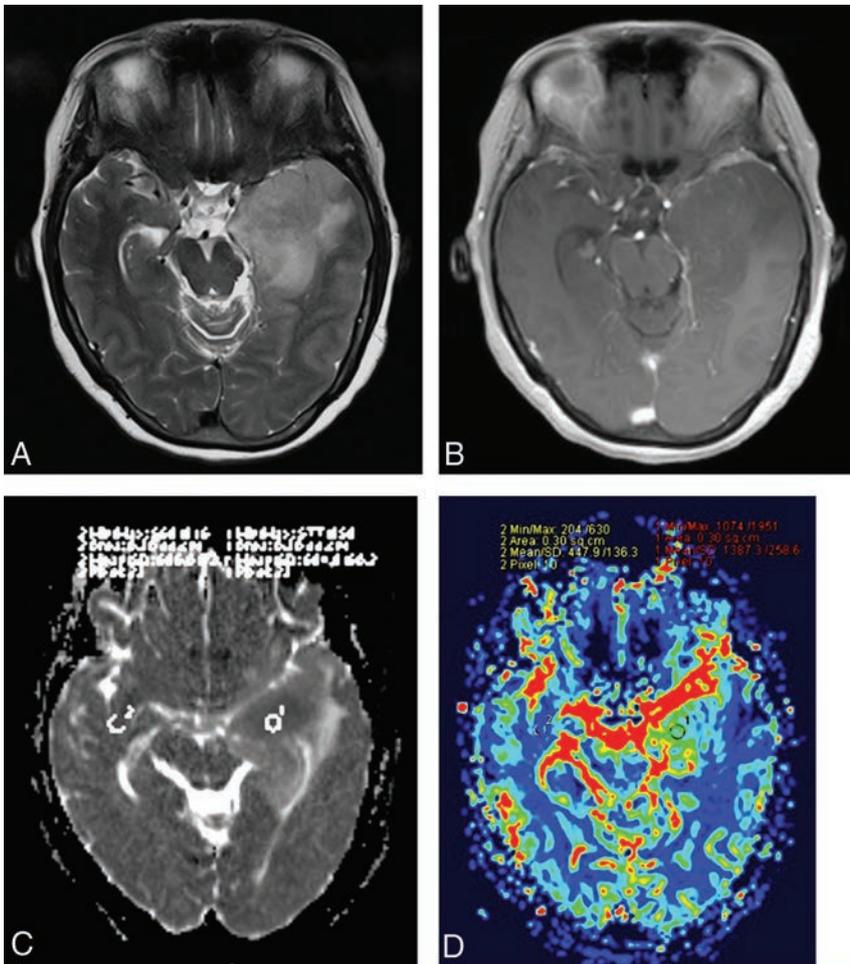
A 52-year-old woman with a diffuse astrocytoma without *IDH* mutation. A, Axial T2WI demonstrates heterogeneous high signal intensity with indistinct borders on the left temporal lobe. B, Contrast-enhanced axial T1-weighted image demonstrates a lesion enhancement with blurred borders. C, A corresponding ADC map shows the tumor with a decreased ADC value ($ADC_{min} = 0.684 \times 10^{-3} \text{ mm}^2/\text{s}$, $rADC = 1.08$). D, Correlative color CBV image shows elevated perfusion with the calculated $rCBV_{max}$ of 3.10.
